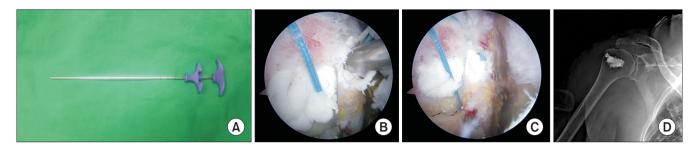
(A) Jamshidi needle which is used for cement insertion. (B) The lateral row anchor is re-inserted and tensioned while the cement is hardened enough. The Jamshidi needle is used to insert additional cement and prevent back out of cement and anchor. (C) Final construct of the anchor hole augmented with a bone cement. (D) Final radiography.
